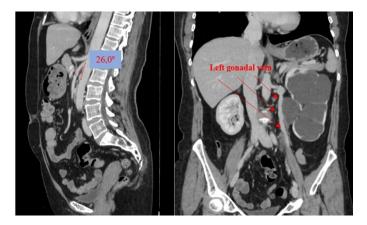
Computed tomography of the abdomen and pelvis: On the left we have a sagittal section in the arterial phase of the contrast medium showing the reduced aorto-mesenteric angle (26 degrees). On the right we have a coronal section in the portal phase of the contrast medium that clearly characterizes the ectasia and early enhancement of the left gonadal vein, this left gonadal vein promoting compression on the left proximal ureter, at the level of the ureteropelvic junction, with consequent hydronephrosis upstream and thinning of the left renal parenchyma.
